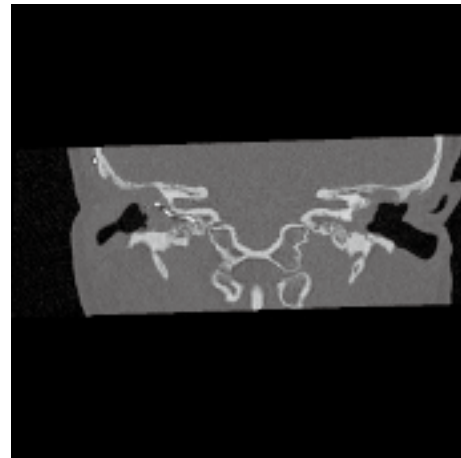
CT scan showing electrode array position changes.
